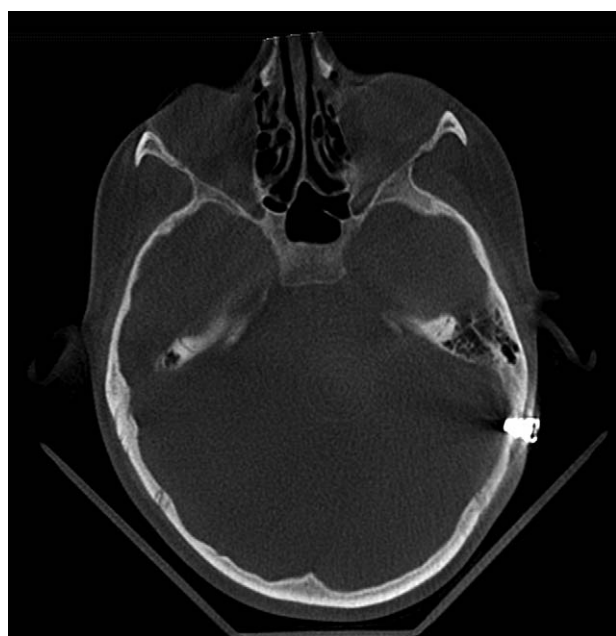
Transversal coupe of CBCT scan in a patient with a BAHl and idiopathic pain. This CBCT slice shows artifacts which impair the image quality around the implant. Since image quality was structurally insufficient among all CBCT scans, (the amount of) bone resorption could not be systematically assessed. CBCT indicates cone beam computed tomography; BAHl, bone-anchored hearing implant.
